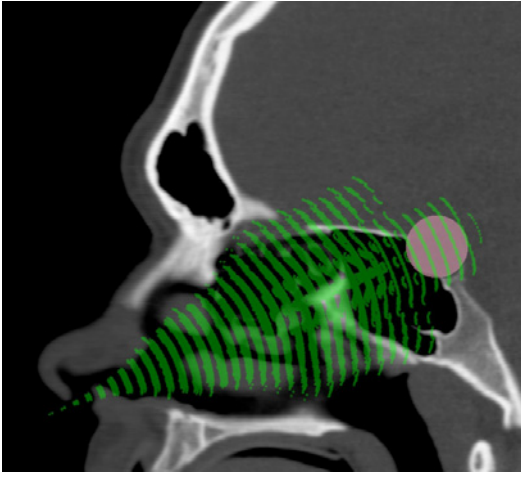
Sagittal CT image with overlaid optimized cannula workspace (green). The pituitary gland is marked by a sphere.
